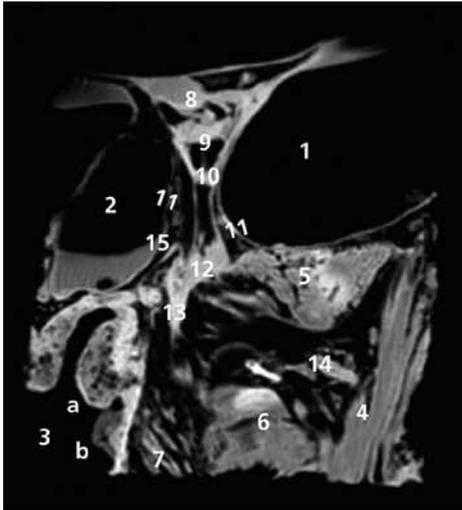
Coronal MR image of left PPF
